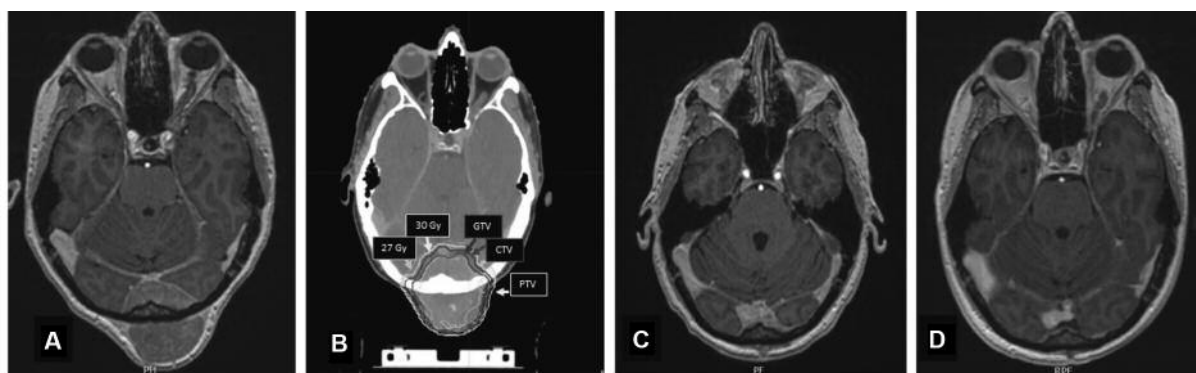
SBRT for a calvarial metastasis from Ewing Sarcoma. A) Occipital mass demonstrated on T1 contrast enhanced axial MRI. B) axial treatment planning CT demonstrating target volumes and treatment isodose lines. C) axial T1 contrast enhanced MRI demonstrating reduction in tumor size 2 months post SBRT. D) axial T1 contrast enhanced MRI demonstrating reduction in tumor size 11 months post SBRT.
